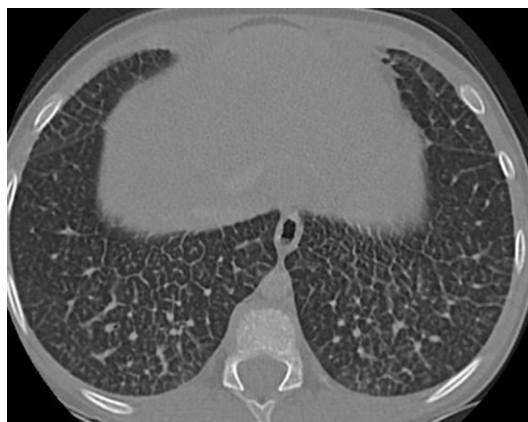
A CT scan with lung window settings revealing diffuse interlobular septal thickening, forming polygonal arcades.
